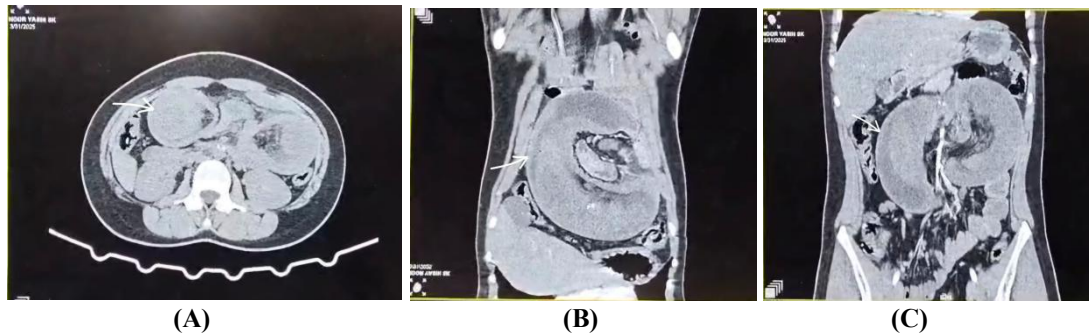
CT scan of abdomen: (A)-axial view, (B), (C)-coronal view, all showing dilated jejunum(arrows) on both sides of abdomen with bowel within bowel configuration [Target sign - in (A) and Pseudokidney sign in (C)] and interbowel fluid
